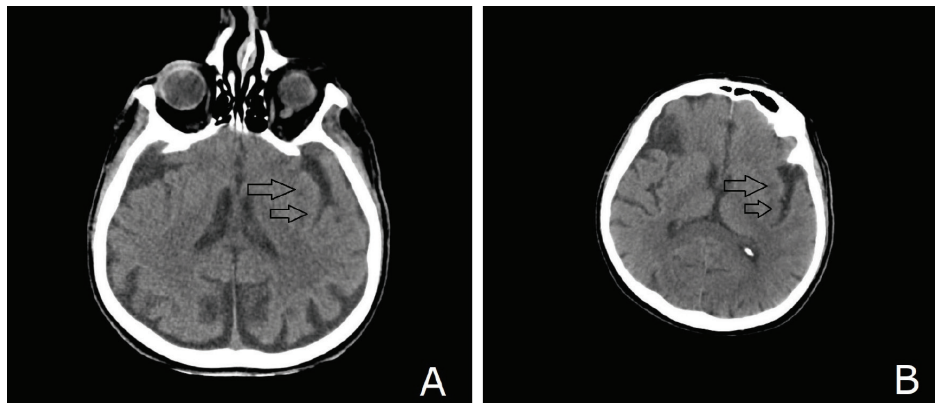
Brain computed tomography: No area of hyperdensity suggesting hemorrhage. Mild edema and asymmetry present in the insular area consistent with early ischemia
